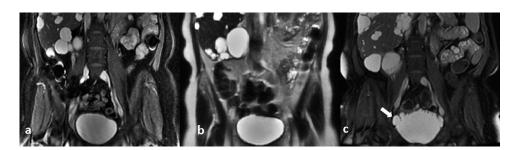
Coronal SSFP MRI of the bladder at 3 time points (a) 2012, (b) 2014, and (c) 2017 after botox injection of bladder wall. Arrow points toward hutch diverticulum.
